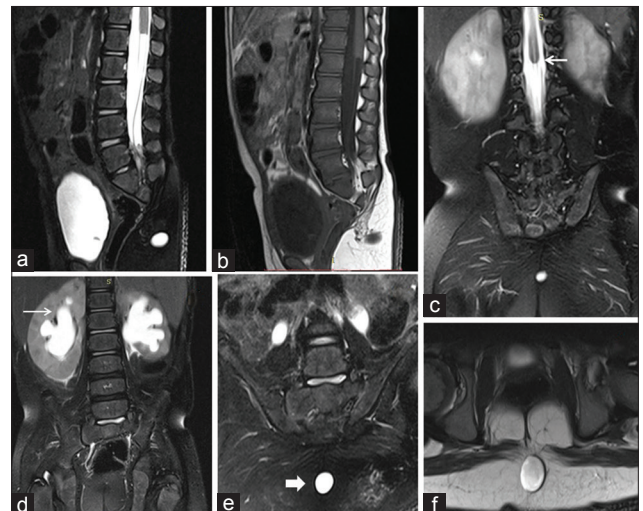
A 3-year-old female child with a shallow natal cleft, (a) sagittal short-tau inversion recovery, (b) T1-weighted image, and (c) coronal short-tau inversion recovery images show sacrococcygeal agenesis with rudimentary S2 vertebra with blind-ended conus (← arrow) representing Type III caudal regression syndrome. (d) Coronal short-tau inversion recovery image shows bilateral hydronephrosis (→ arrow). (e) Coronal short-tau inversion recovery and (f) axial T2-weighted images T2 hyperintense midline cystic lesion in intergluteal cleft (→ block arrow).
